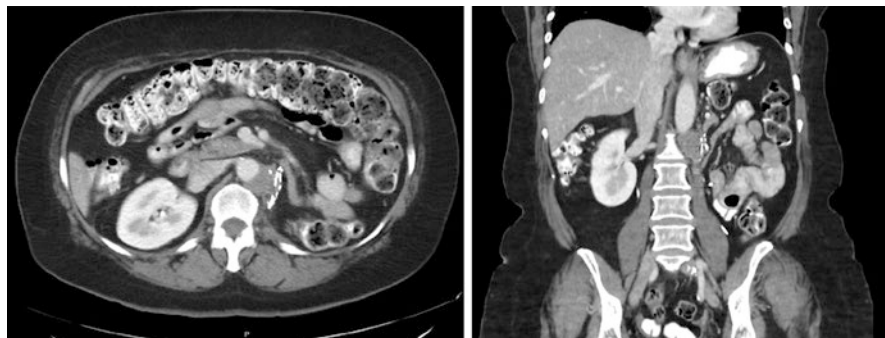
Computed tomography imaging of a patient with recurrent renal cell carcinoma at previous resection bed abutting the abdominal aorta
